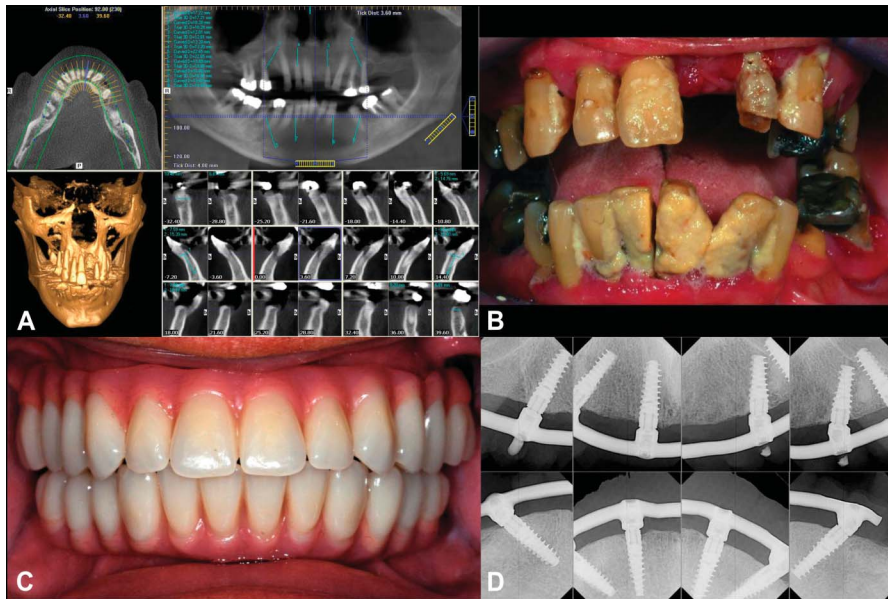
A and B, Clinical and radiographic images showing the preoperative condition of a 62-year-old patient for whom treatment with the placement of 4 implants in each jaw to support fixed restorations was planned. C and D, Postoperative clinical and radiographic views of the same patient who was treated according to the All-on-4 treatment concept, at 24 months postloading.
